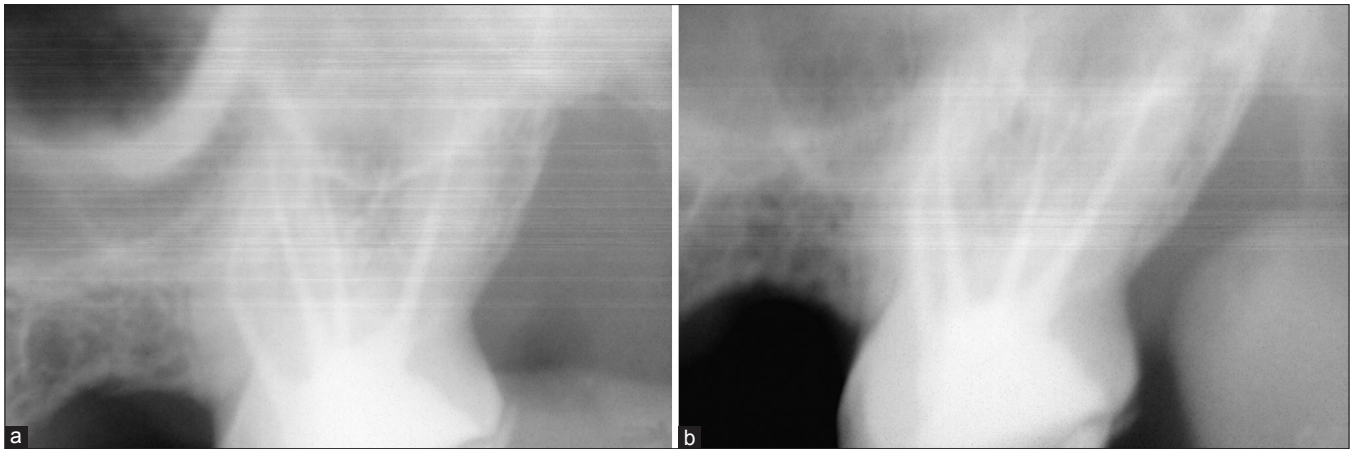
Post-operative radiographs (a) immediately after treatment, (b) after two months
